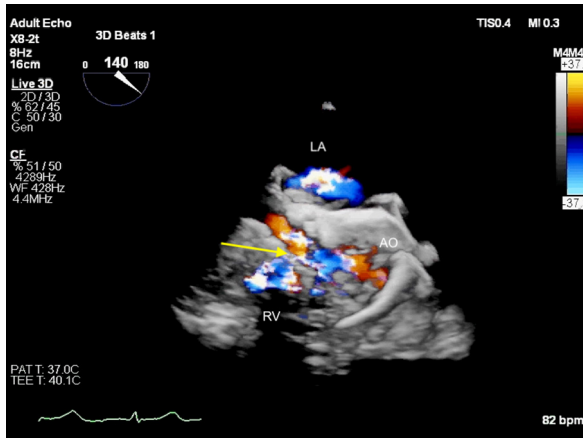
Three-dimensional TEE, midesophageal volume-rendered image with color flow Doppler demonstrates the ARV fistula (arrow). AO, Aorta; LA, left atrium.
